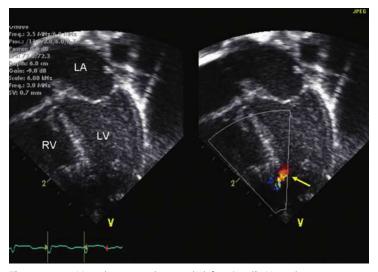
Muscular ventricular septal defect (small). Note that no apparent defect in the ventricular septum could be visualized by two-dimensional image *(left)* on the apical four-chamber view. However, a color Doppler image *(right)* identifies a small defect in the muscular septum near the apex by showing a left-to-right jet *(arrow)*. LA, left atrium; LV, left ventricle; RV, right ventricle.
